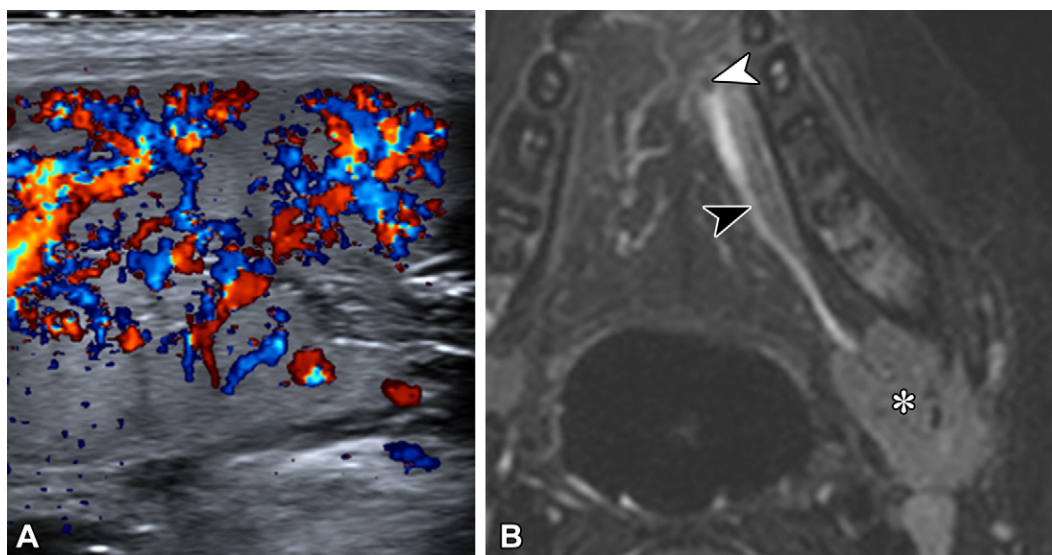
Sialadenitis in two pediatric patients. (A) Transverse color Doppler US image in a 6-year-old boy with neck swelling shows an enlarged, heterogeneous, hyperemic submandibular gland. (B) Axial T2W FS MR image in a 7-year-old boy with recurrent pain and swelling under the tongue shows a mildly edematous left submandibular gland (*) and dilatation of the Wharton duct (black arrowhead) secondary to an obstructive calculus (white arrowhead). Sialadenitis due to obstructing calculus is rarer in children than in adults.
